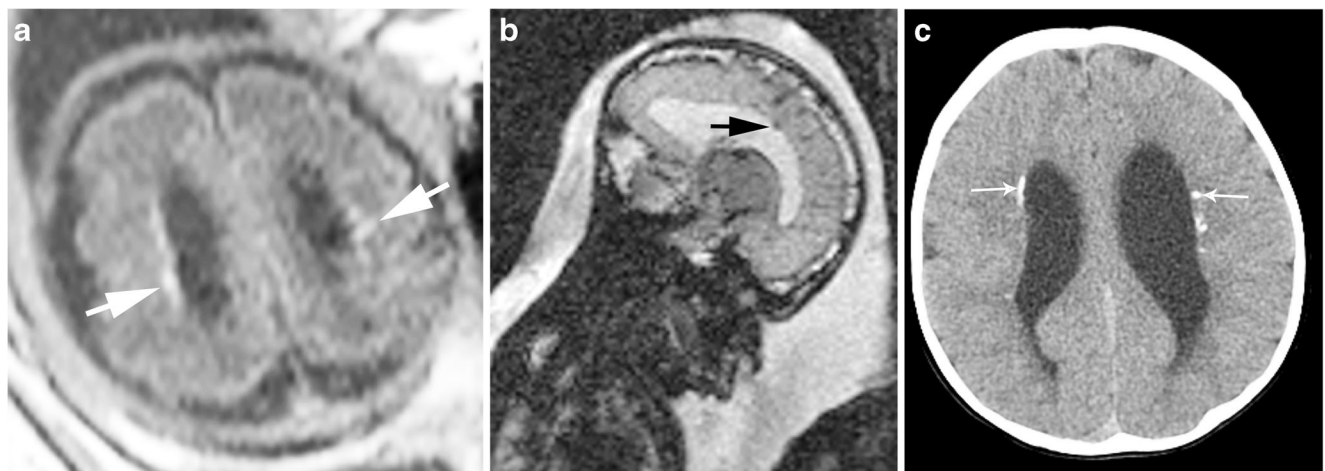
Lymphocytic choriomeningitis virus in a 30-week gestational age fetus and post-natal follow-up. a, b Axial T1-weighted fetal MR image (a) shows fine areas of hyperintensity throughout the periventricular regions (*white arrows*) that demonstrate susceptibility effect on (b)
